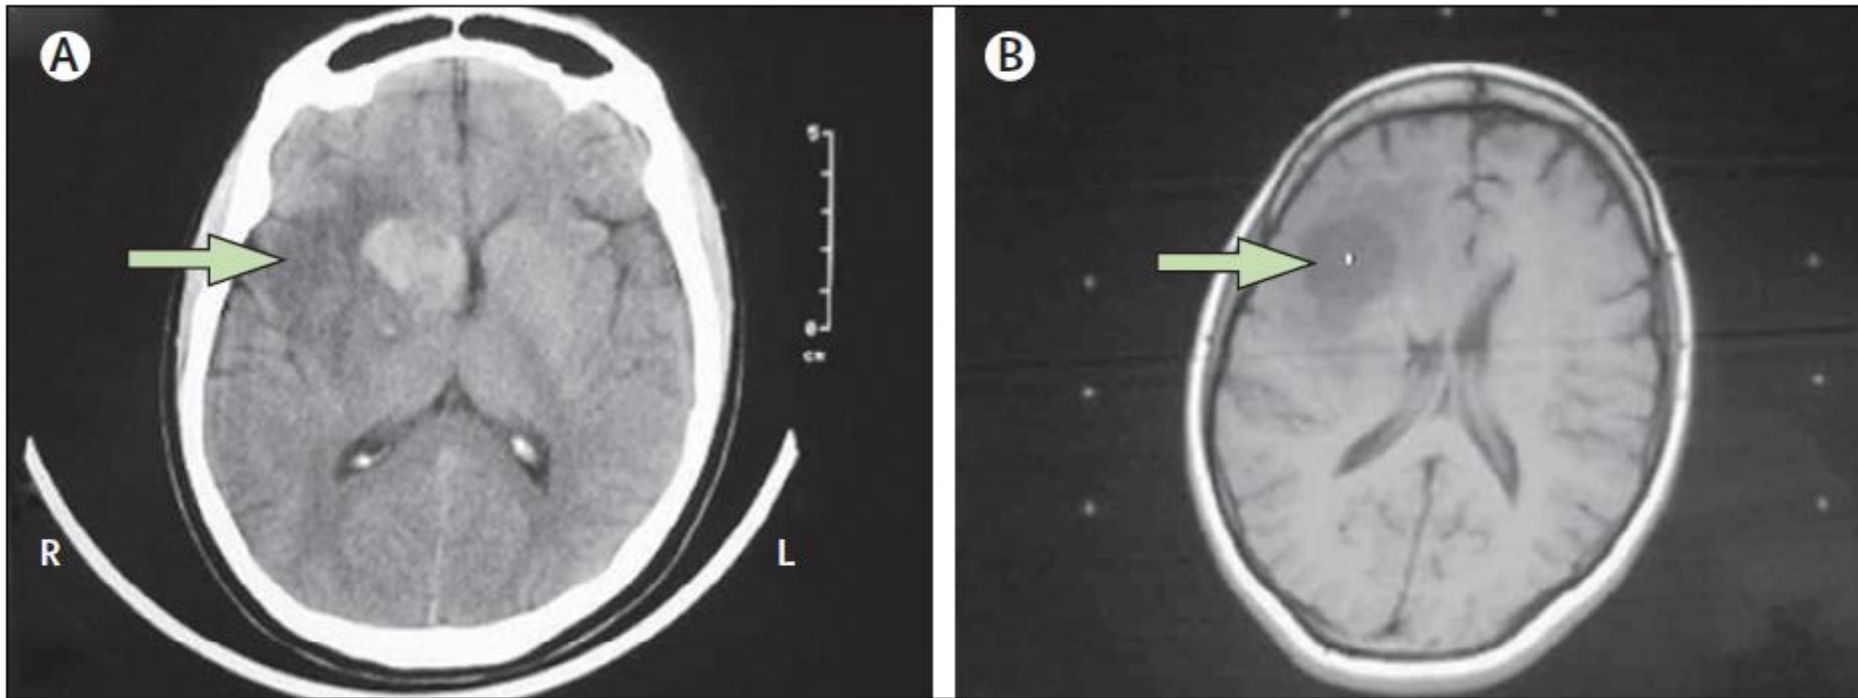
CT scans of the patient's head
